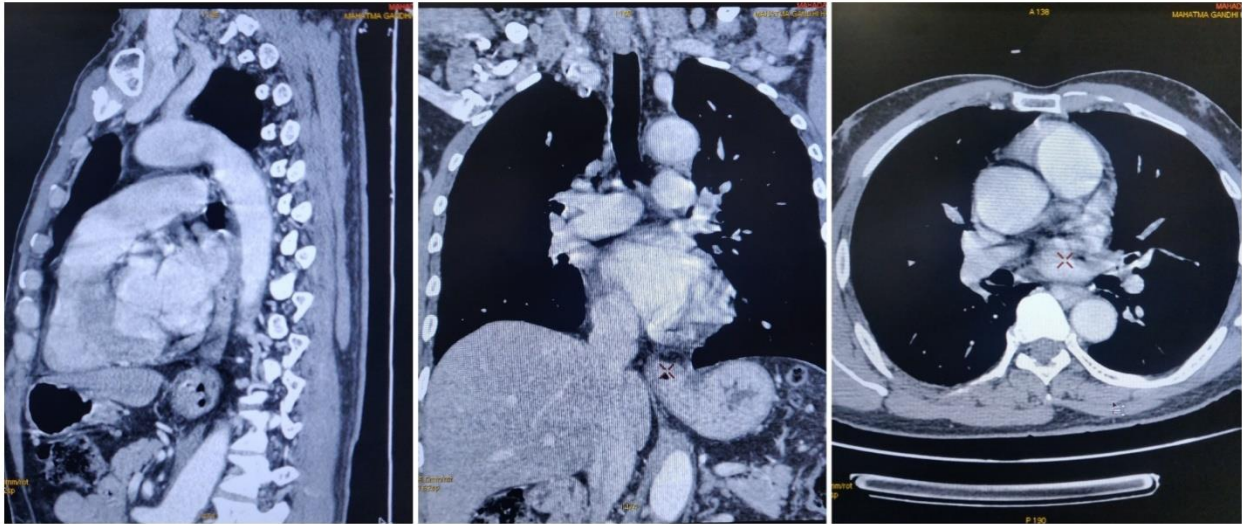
Contrast enhanced CT (CECT) scan image shows that there is irregular homogenous circumferential mass lesion with lumen narrowing in lower one third of oesophagus with involvement of GE junction and part of fundus of stomach.
